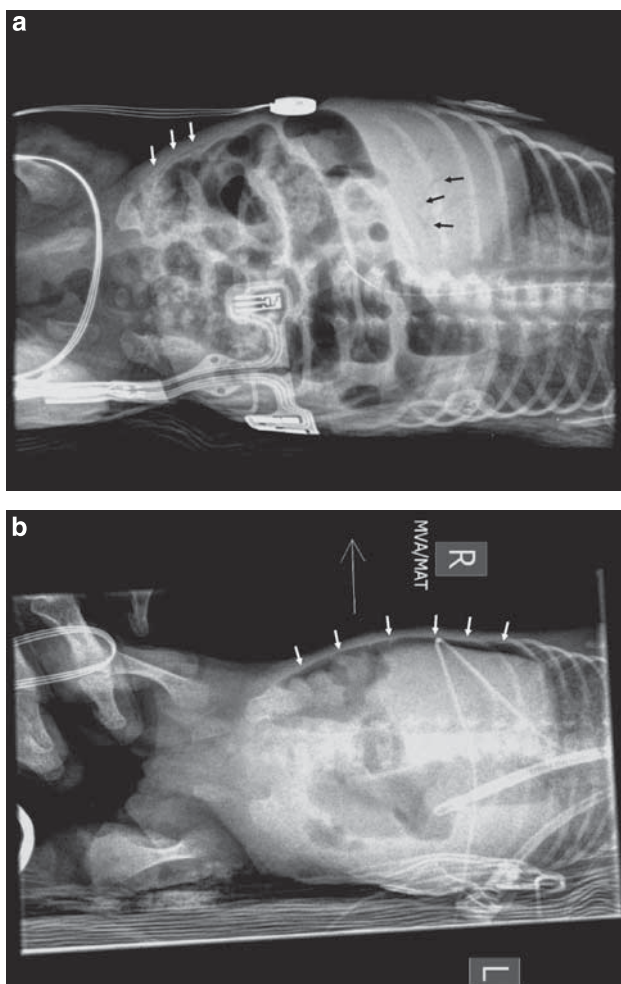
Abdominal X-ray image showing signs of necrotizing enterocolitis. (a) Pneumatosis intestinalis and portal venous gas and (b) pneumoperitoneum.
